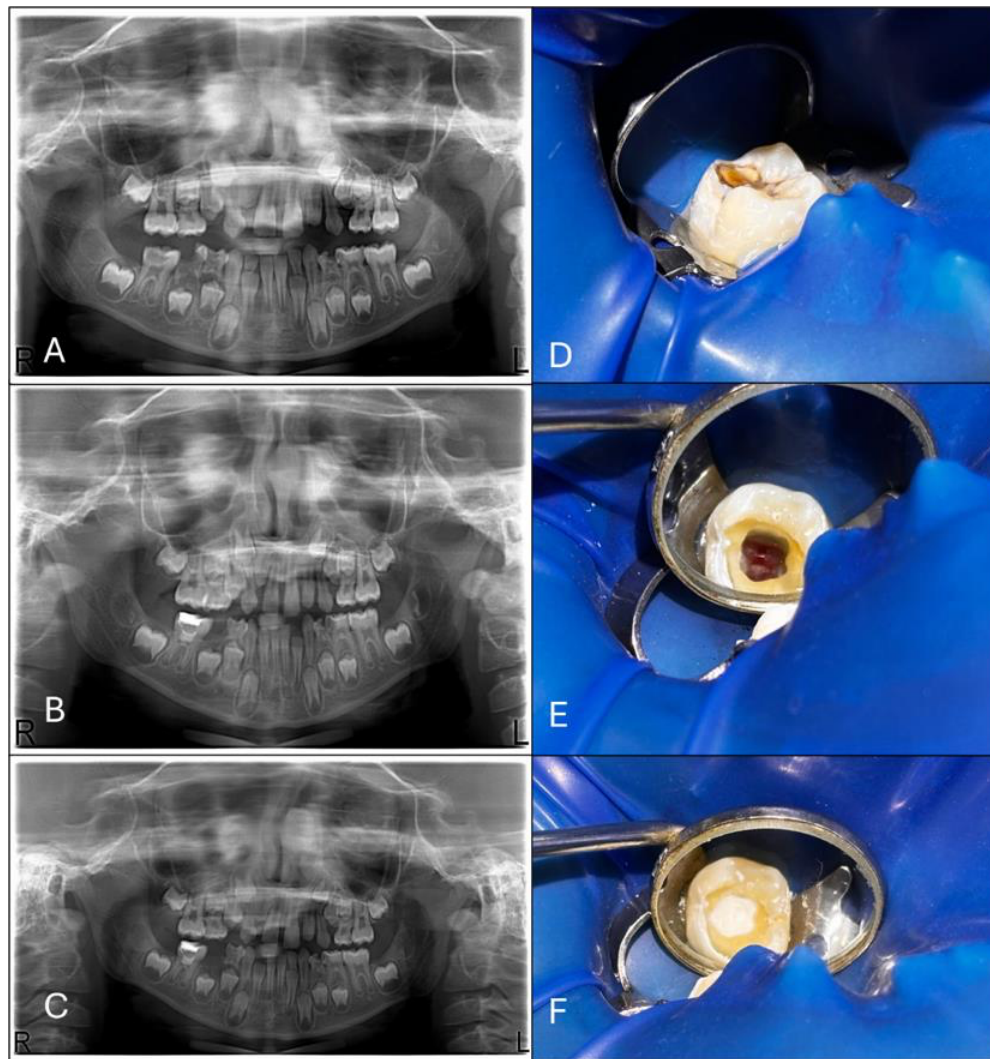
Clinical and radiographic follow-up of a full pulpotomy case in tooth 46 diagnosed with irreversible pulpitis. (A) Preoperative panoramic radiograph. (B) Three-month follow-up. (C) Six-month follow-up. (D) Clinical view prior to pulpotomy. (E) Pulp chamber following coronal pulp removal and hemostasis. (F) Final view after placement of MTA.
